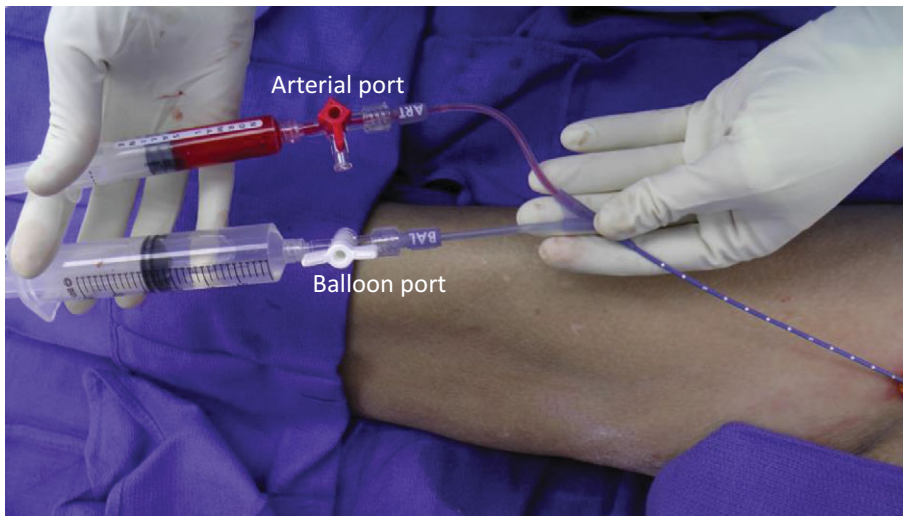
The arterial port is flushed and used for continuous arterial pressure monitoring. The balloon is inflated using diluted contrast and balloon placement and morphology are confirmed by X-ray or fluoroscopy.
